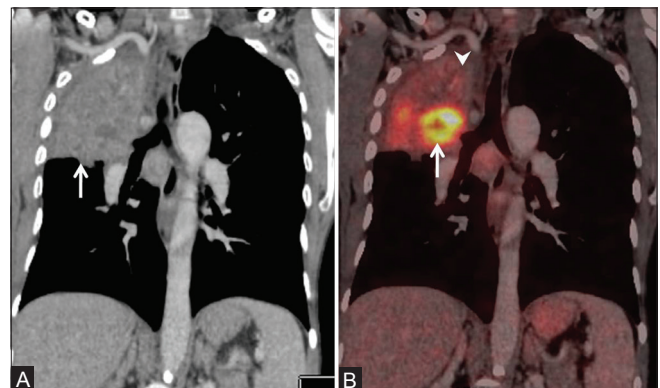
(A and B): Role of FDG PET/CT in primary tumor delineation. Irregular soft tissue opacity seen on coronal CT scan (arrow, A) with no obvious demarcation between the tumor and surrounding consolidation. PET/CT shows the FDG-avid tumor (arrow, B) separate from the non-FDG-avid consolidation (arrowhead, B)
